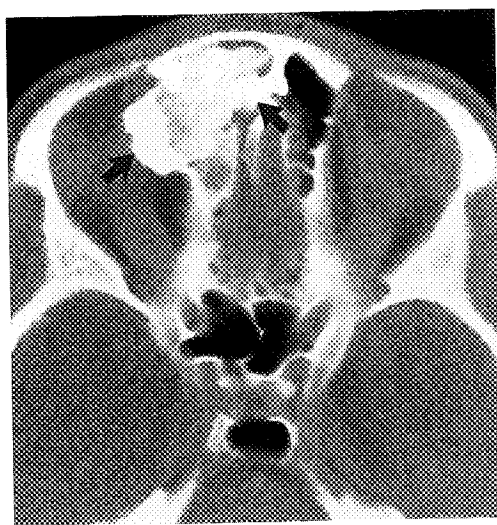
CT scan shows an ivory osteoma (arrows).
